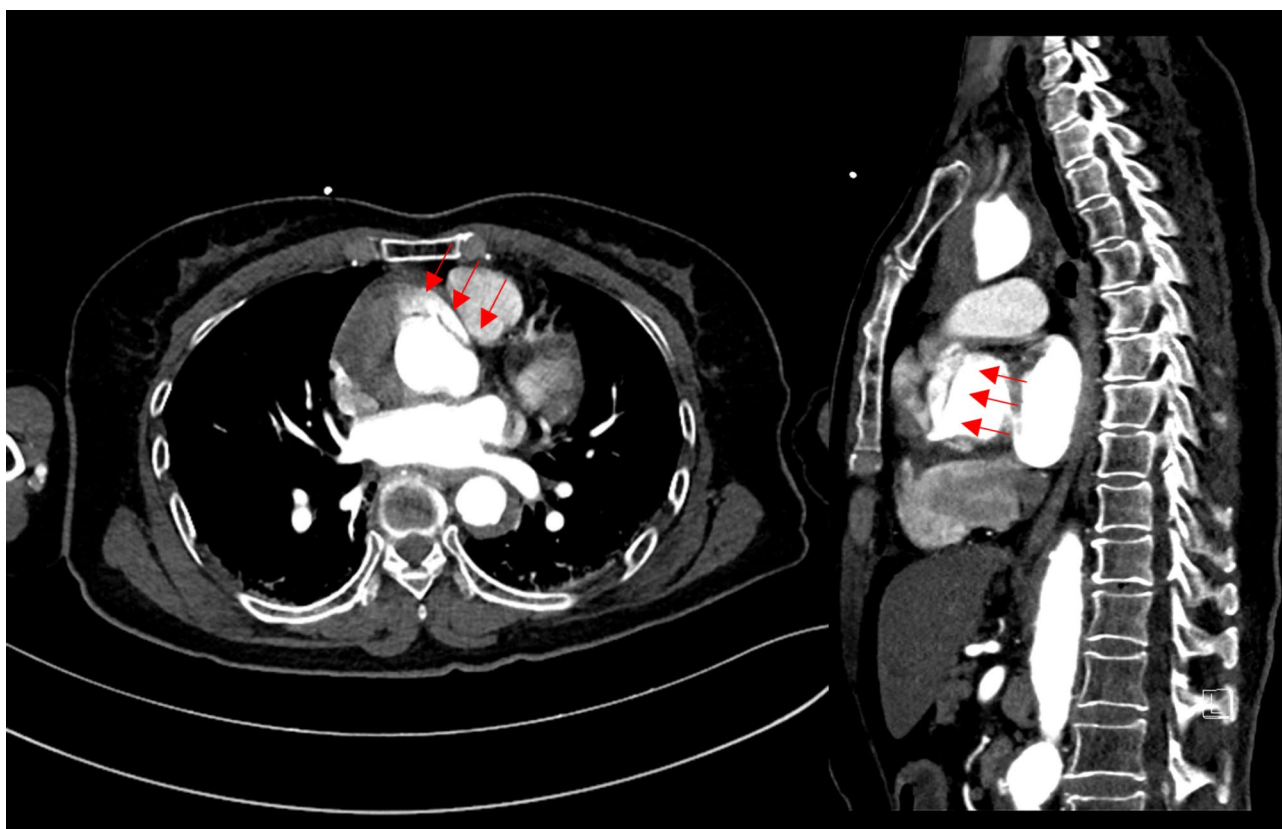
Axial and sagittal views of aorta CT indicate the dissection flap in ascending aorta (red arrows)
